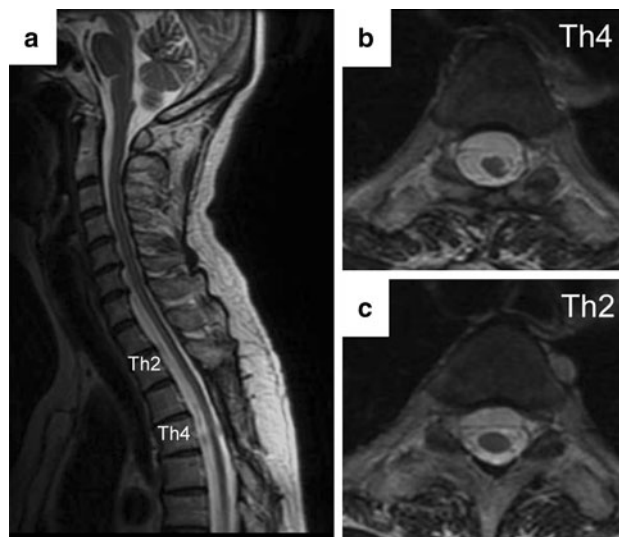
Representative postoperative sagittal (a) and axial (b, c) T2-weighted MR images of the thoracic spinal cord, demonstrating that the spinal cord was reduced to its normal position (a, b) and that there was a CSF pooling at the ventral side of the spinal canal (a, c)
